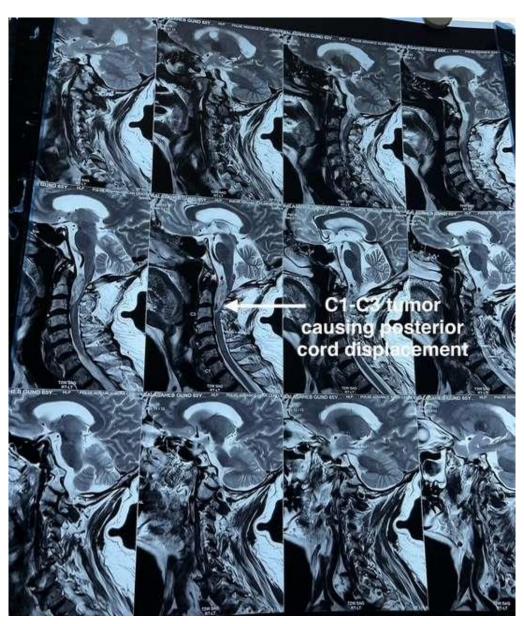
MRI cervical spine showing tumor
